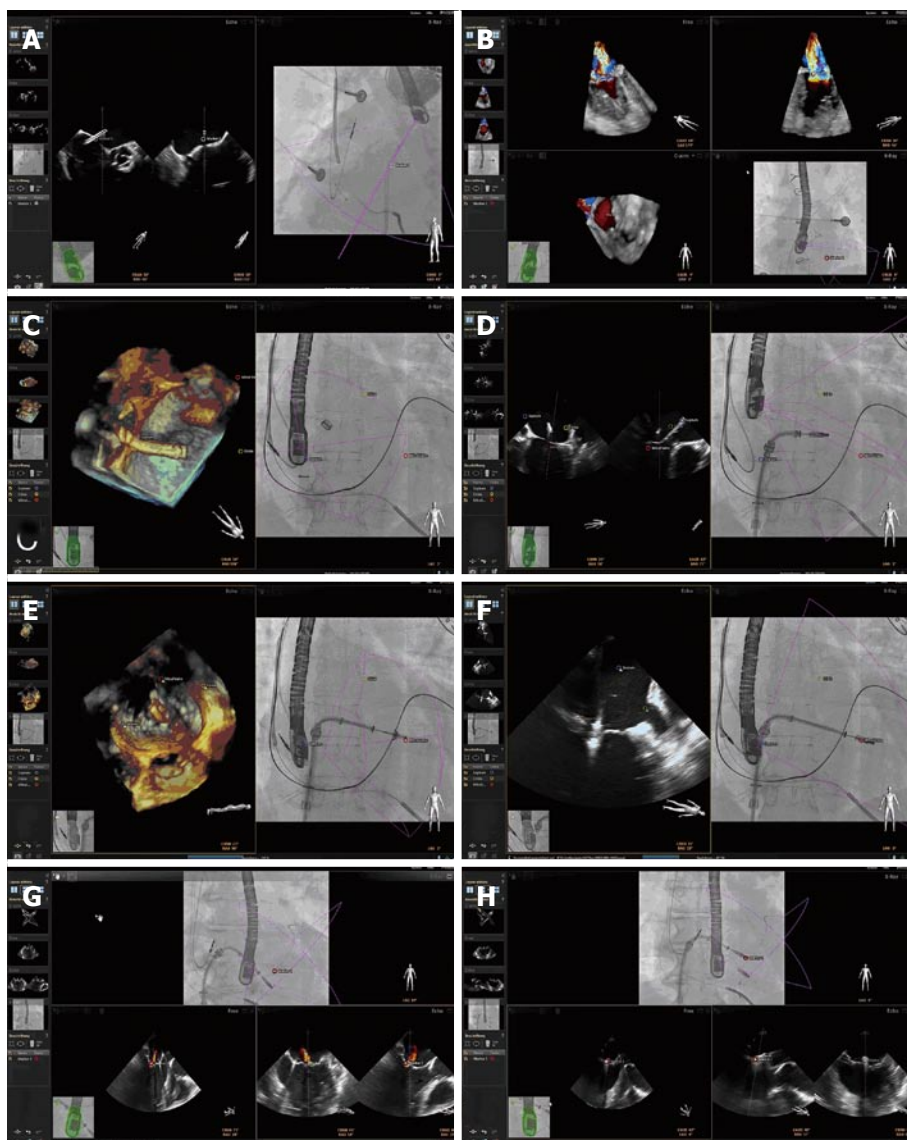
EchoNavigator® during MitraClip® procedures. A demonstrates the Echo-view on the left, depicting an X-plane-view of the interatrial septum. The interventionalist can set markers in this view for exact delineation of the optimal puncture site that will automatically appear in the X-ray-view on the right. A 3D full volume color doppler image is shown in the right upper panel of B. After cropping into this data set, the maximum regurgitant jet was depicted and marked within this image. On the left side of C, a 3D view of the septum with the delivery system and especially the three points of interest (Septum, Crista, and Mitral valve) is demonstrated. The connection between these three points creates a virtual triangle in the X-ray-view on the right side of C, outlining the area at risk outside this triangle in the X-ray-view in D, where contact of the MitraClip® device with its surrounding structures potentially can lead to complications, such as perforation with cardiac tamponade. E demonstrate the process of Clip orientation orthogonally towards the commissure in the 3D view, and the grasping of leaflets in the 2D intercommissural view in F. The X-ray-view in both figures on the right display demonstrates the correct position of the Clip right on top of the red marker, corresponding with the echo images. G demonstrates the residual regurgitant jet on the lateral side of the first Clip. This jet was marked in the echo image and was then used for orientating a second Clip in the X-Ray image, as demonstrated in H. 2D: Two-dimensional; 3D: Three-dimensional.
